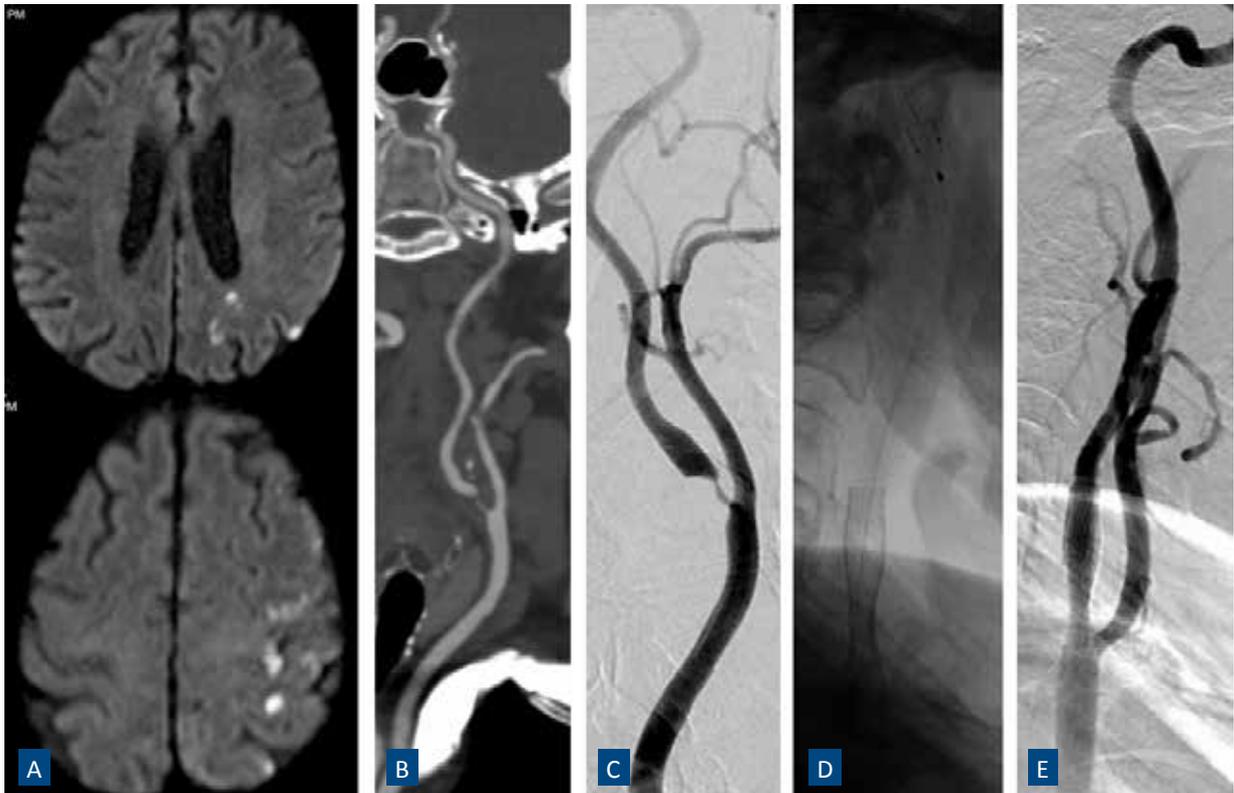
76-year old female presented with multiple episodes of recurring left sided weakness, increasing in severity. A - MRI diffusion weighted image showing small foci of infarction in left parietal & frontal lobes. B- CT angiography and C- Carotid angiography revealing severe stenosis at origin of left internal carotid artery (arrow). Patient was at high risk of major stroke. D- Carotid stent placement (arrow, D) was performed with help of protection device (double arrow). E – Final angiogram showing well open carotid artery.
